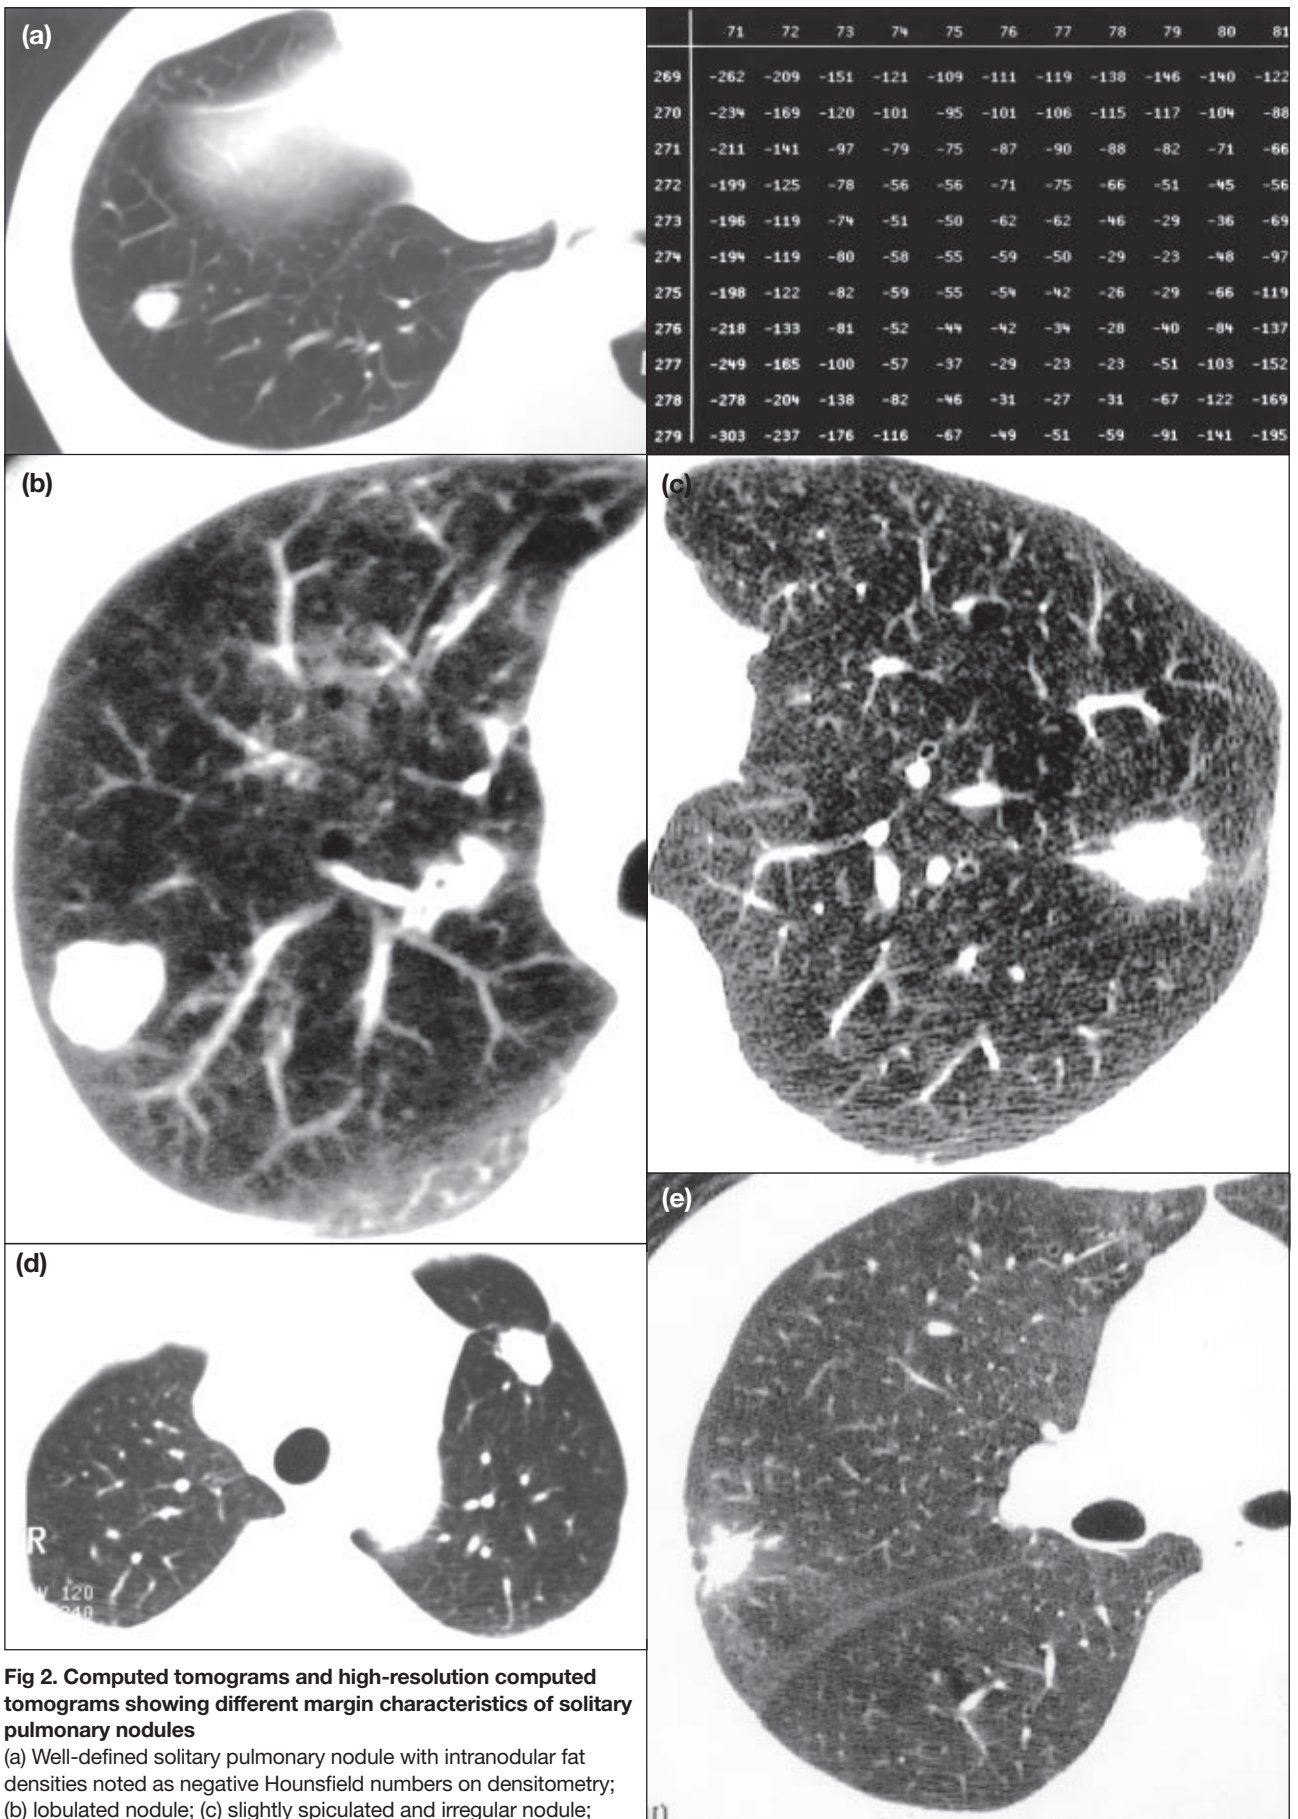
Computed tomograms and high-resolution computed tomograms showing different margin characteristics of solitary pulmonary nodules
